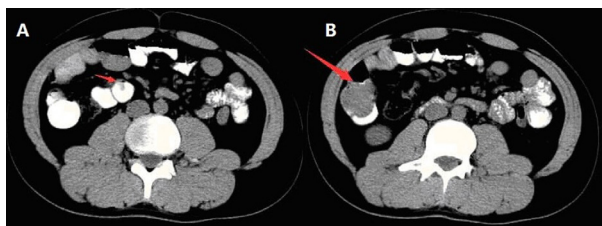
Computed tomography scans of the abdomen. Red arrows point to polyps.
